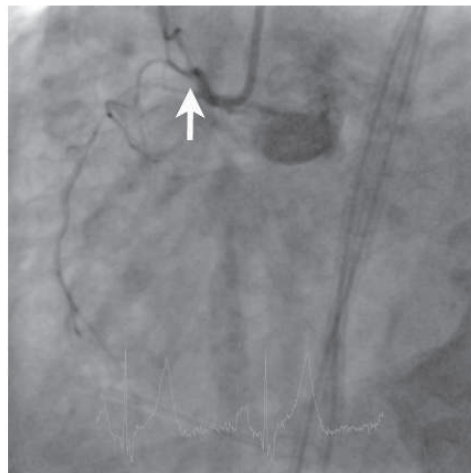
Example of a 68-year-old patient with PAOD. (a) Coronary CT angiography. White arrow points to a soft plaque in the proximal right coronary artery, narrowing the lumen more than 50 %. (b) Short axis image of the adenosine perfusion MRI examination. White arrow points to a perfusion defect of the inferior wall during stress. This perfusion was not present in rest, indicating reversible ischemia. (c) Invasive coronary angiography image of the right coronary artery. The right coronary artery is proximally occluded (white arrow). No percutaneous intervention was possible at this stage. Due to the asymptomatic status and good collateral circulation (visible as contrast filling distal to the occlusion), no surgery was performed.
